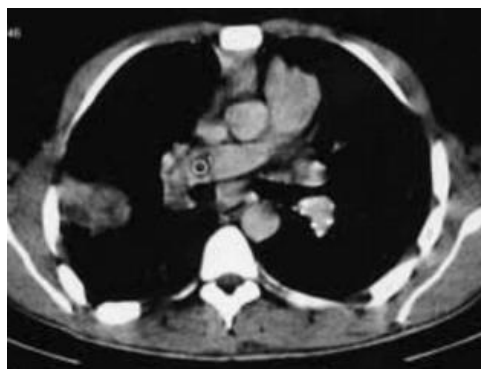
Thoracic CT scan. Cystic formation of 2 cm in diameter in the right pulmonary artery
